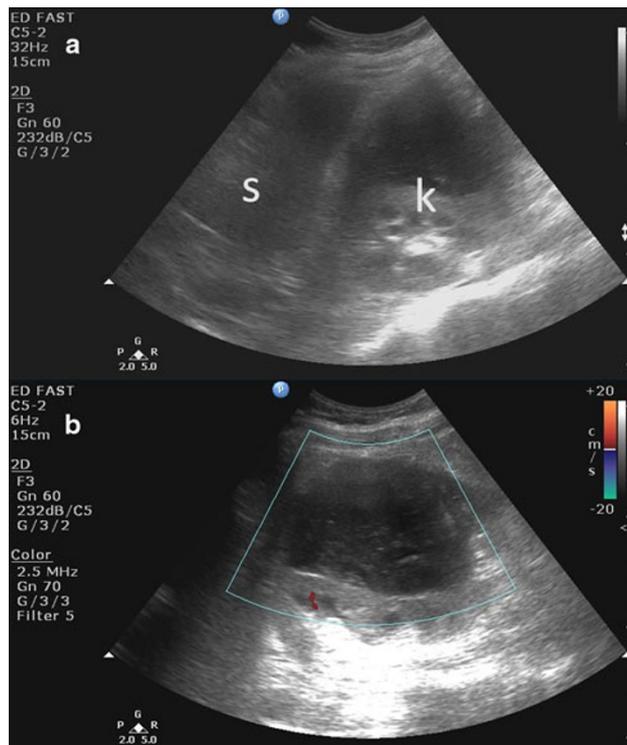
a Sonographic perisplenic window, coronal plane; (s: spleen, k: kidney). Note the mixed echogenicity in the upper portion of the left kidney in this image. b Perisplenic window, coronal plane of predominately the left kidney
